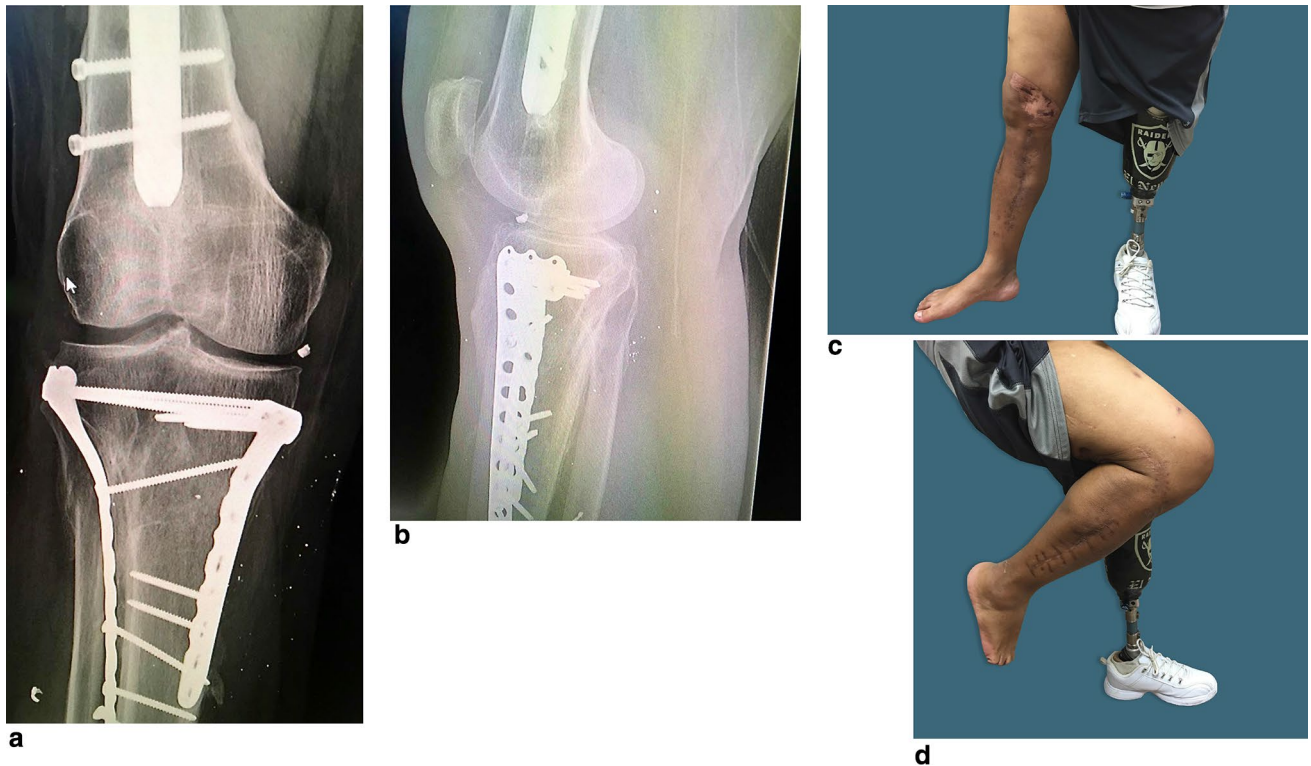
Results of previous patient. Clockwise, from left: a AP and b lateral radiographs showing plate and screw implants. c Medial and d lateral photographs showing healing and degree of knee flexion after fasciotomy and fixation
